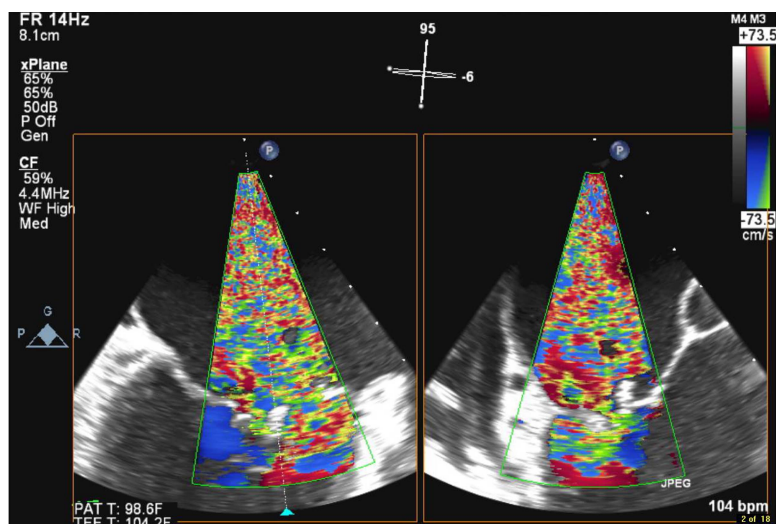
Severe mitral regurgitation flow by transoesophageal echocardiogram.
